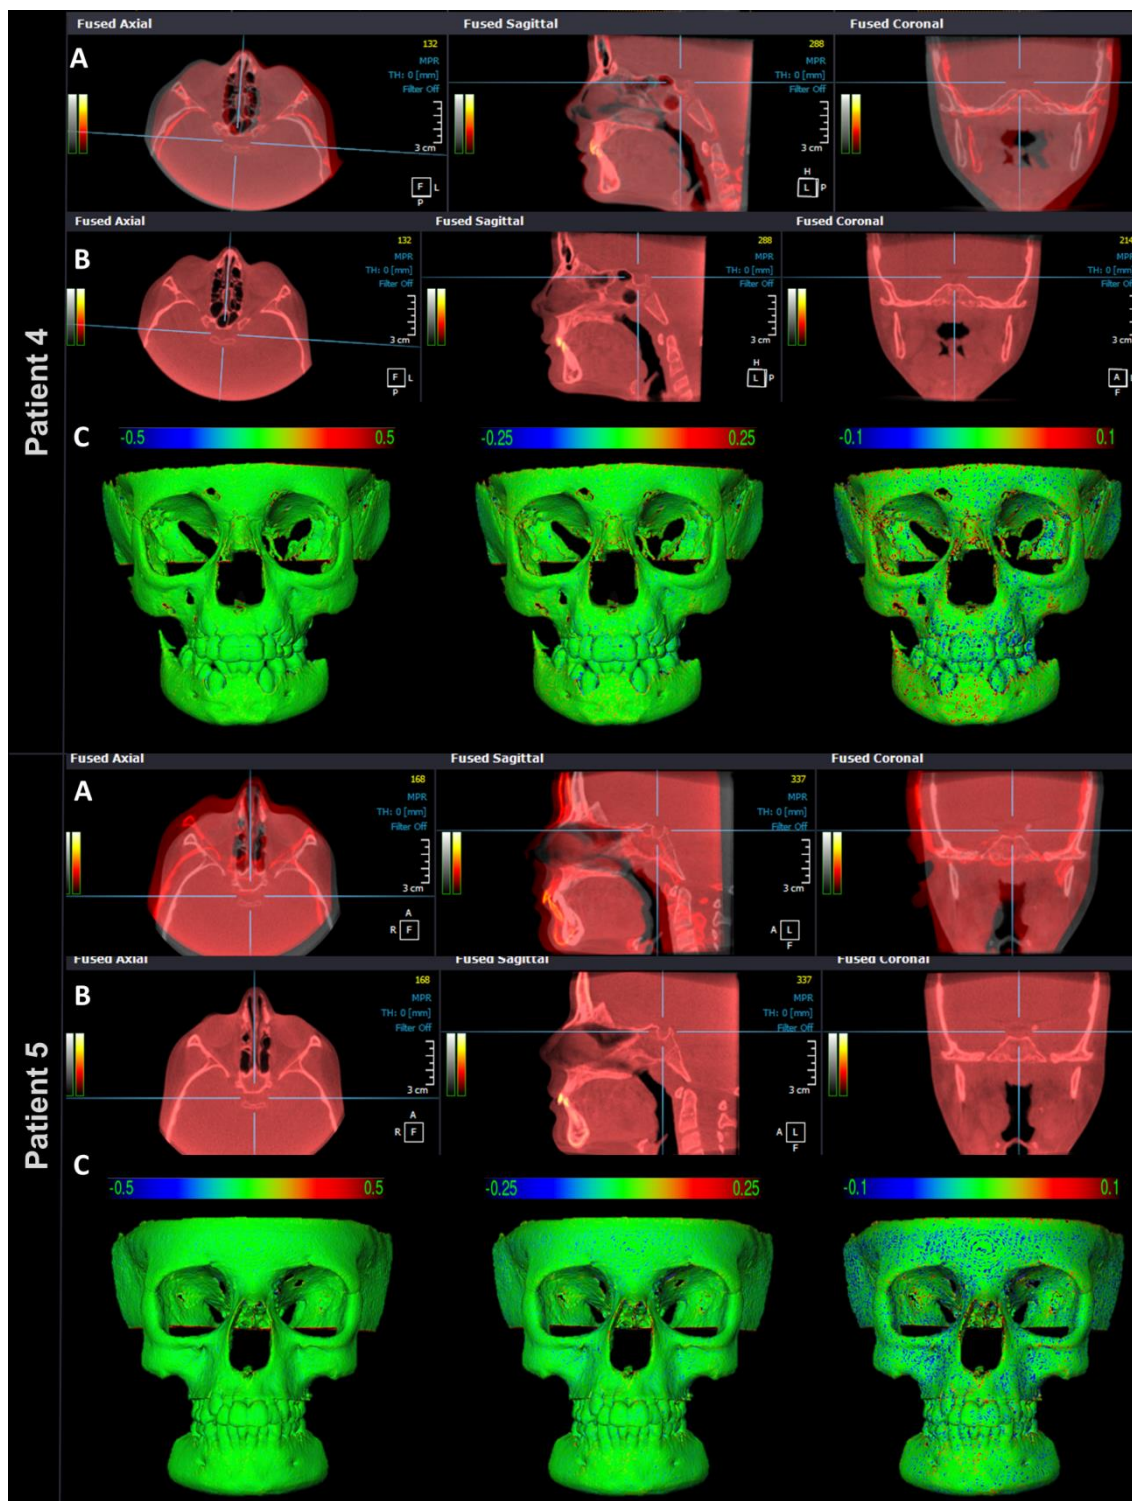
Patients 4 and 5, (A) multiplanar slices of CBCT volumes before cranial base superimposition and (B) after cranial base superimposition, in Ondemand3D, showing the complete correspondence of registration in all areas (C) Skull models after superimposition showing 3D displacements (registration error) via color maps with scale of 0.5mm, 0.25mm and 0.01mm. Positive and negative values indicate outward (red) and inward (blue) changes, respectively. Note the error was less than 0.25mm (CMF application software).
